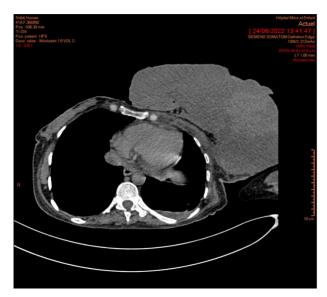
CT scan without contrast
